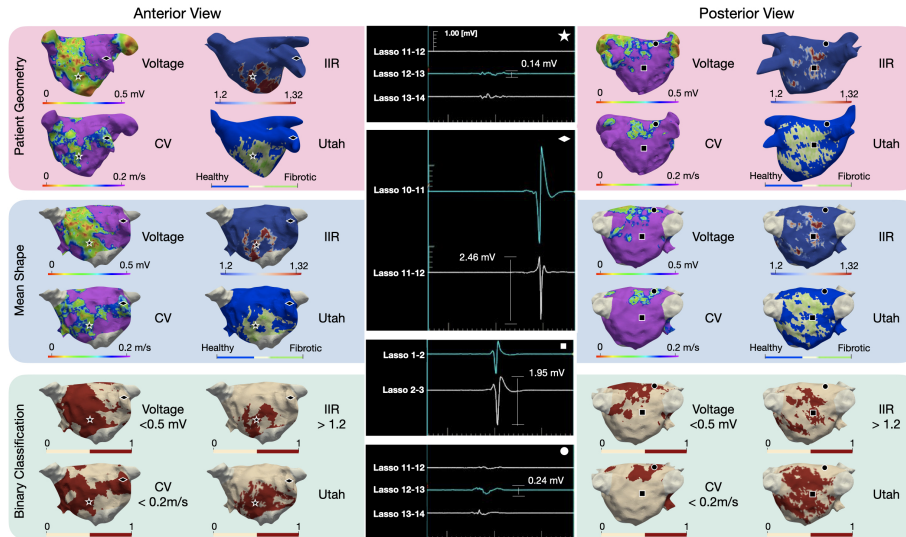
Three-dimensional distribution of voltage $<0.5\text{ mV}$, CV $<0.2\text{ m/s}$ and LGE-areas detected with IIR 1.2-1.32 and the Utah method in a representative patient. The top and middle row show the EAM and LGE-MRI information on the patient's geometry and the mean shape, respectively. The bottom row shows a binary classification, where pathological substrate is shown in red and healthy tissue in cream. Each geometric shape represents a point on the map where the corresponding electrogram is shown in the middle column.
